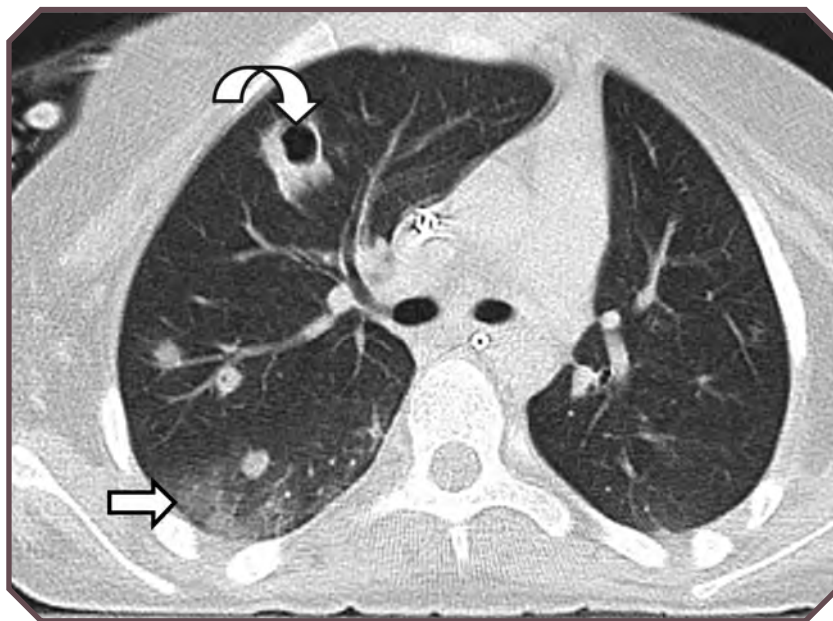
Invasive aspergillosis pneumonia in an immunocompromised patient. Axial chest computed tomographic scan demonstrates multiple focal nodules throughout the right lung, a thick-walled cavitory lesion in the middle lobe (curved arrow), and a region of ground-glass opacity in the superior segment of the right lower lobe (straight arrow).
